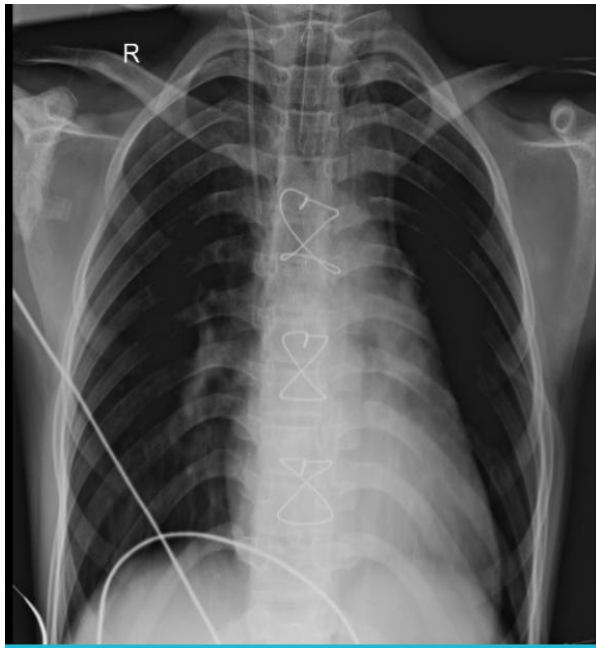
Post-operative x-ray showing presence of ET tube and mid sternal sutures
